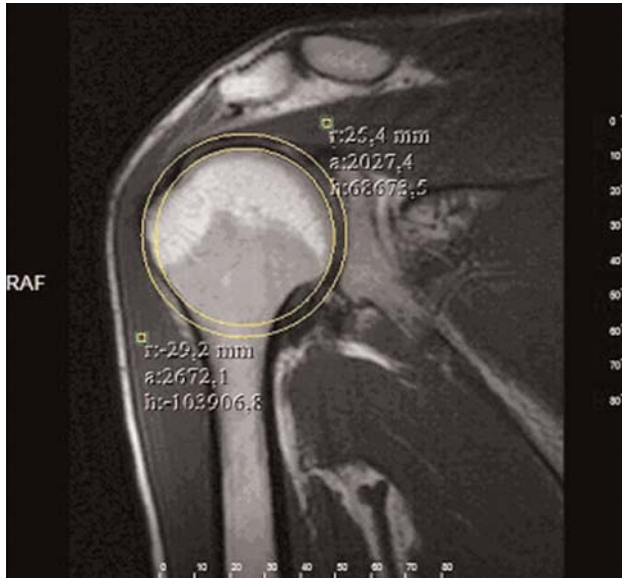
Measurement of the diameters of the humeral head and the glenoid articular surface on coronal T1-weighted image (yellow circles). [Color figure can be viewed in the online issue, which is available at www.aott.org.tr]
